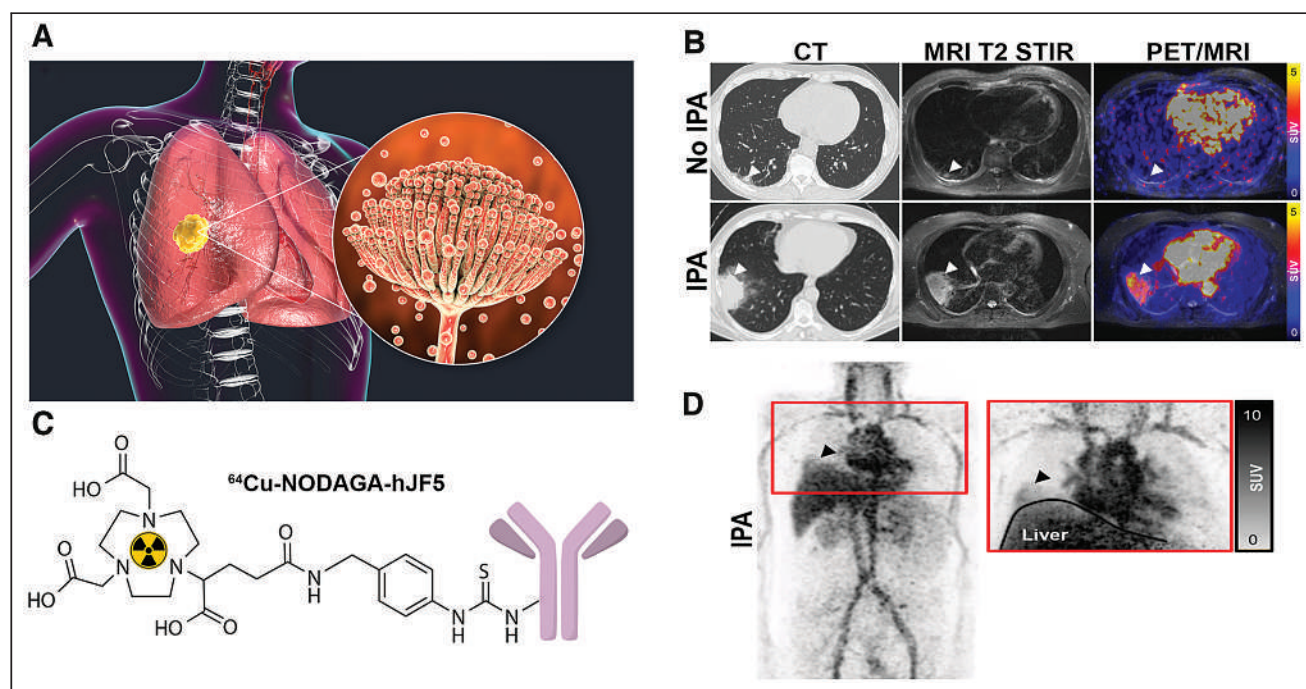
(A) Inhaled spores of opportunistic fungal pathogen *Aspergillus fumigatus* (inset) can lead to IPA in AML patients. (B) Immuno-PET/MRI of patient 1 (no IPA) shows no tracer uptake in lung lesion (arrowheads); patient 2, diagnosed with IPA, shows enhanced tracer uptake in pulmonary lesion of right lower lobe (arrowheads). CT scans were acquired 1 wk before PET/MRI. (C) Chemical structure is shown for *Aspergillus*-specific radiotracer ⁶⁴Cu-NODAGA-hJF5. (D) Maximum-intensity projection of ⁶⁴Cu-NODAGA-hJF5 in patient 2 shows pulmonary lesion (arrowheads).
